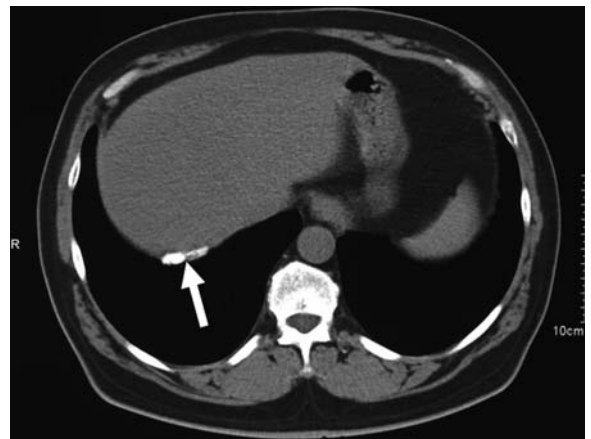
Computed tomography scan of the chest shows calcified diaphragmatic pleural plaque appearing as a discrete line of calcium attenuation (*arrow*)
